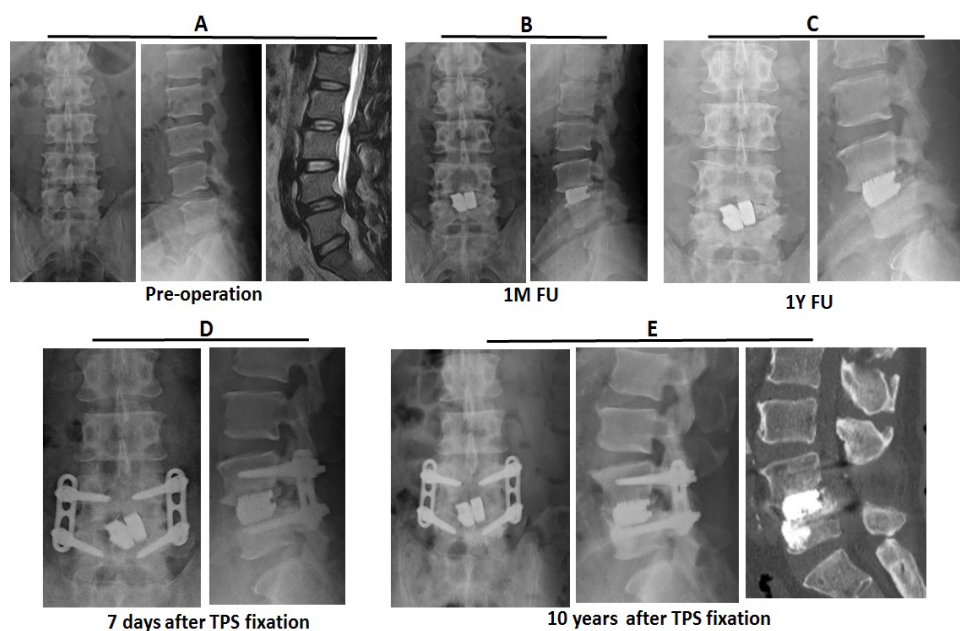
A 54-year-old male with L4/5 DLS and spinal stenosis (A) received CLIF (B). The cement-loosening with instability of cage-cement complex (C) was noted after a severe traffic accident. He received posterior instrumentation one year post-operatively. The radiographs showed 7-days (D) and 10-year (E) follow-up after trans-pedicle screw fixation.
